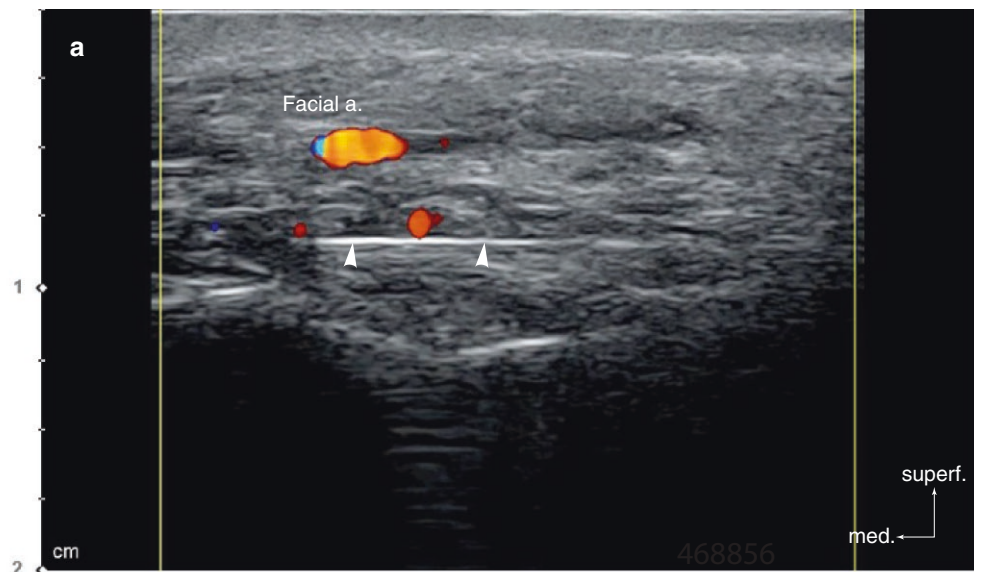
Ultrasonography-guided HA filler removal underneath the nasolabial fold. (a) Compartmented filler, Doppler mode (transverse view, 15 MHz by linear transducer), (b) superficial part, B mode (transverse view, 15 MHz by linear transducer), and (c) deep part, B mode (transverse view, 15 MHz by linear transducer) (yellow arrowheads: HA filler, white arrowheads: injection needle). (Published with kind permission of © Ji-Soo Kim 2020. All Rights Reserved)
